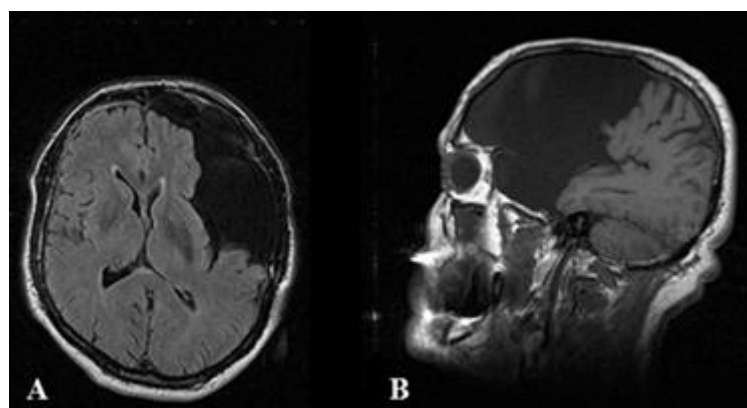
MRI of arachnoid cyst in the left Sylvian fissure:
